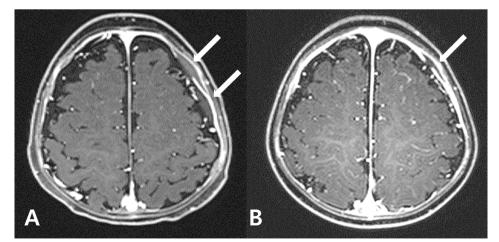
Magnetic resonance imaging of the brain shows the epidural fluid collection with pachymeningeal thickening on the left frontoparietal lobe on hospital day 3 (A), and on hospital day 16 (B). A and B are axial T1-weighted post-contrast images.
